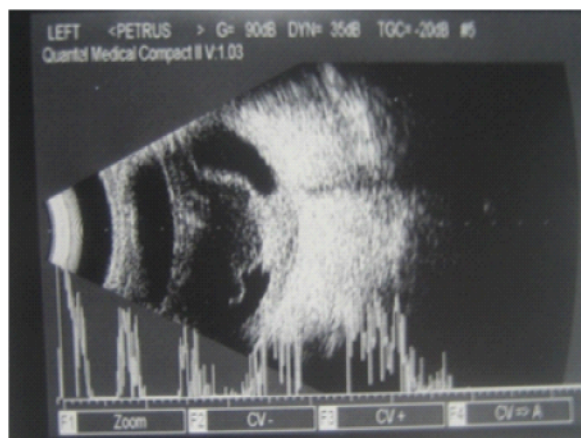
Ultrasonography result of non-retinoblastoma case, there is no density higher than the sclera and high internal reflectivity
